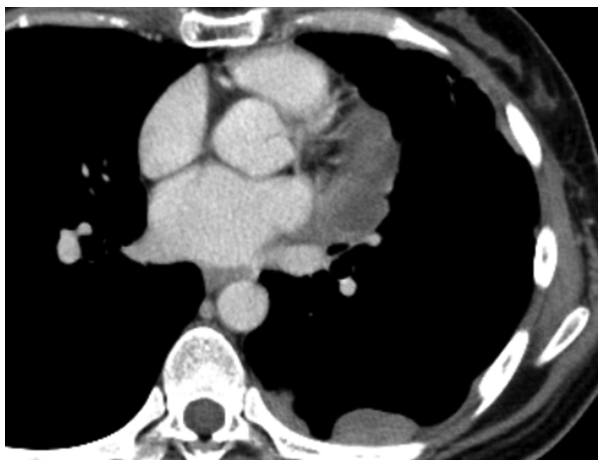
The preoperative chest computed tomography (CT). The CT image shows disseminated nodules in the left pleural cavity. We detected tumours that were adjacent to the pericardium, which indicated the possibility of pericardium invasion.
